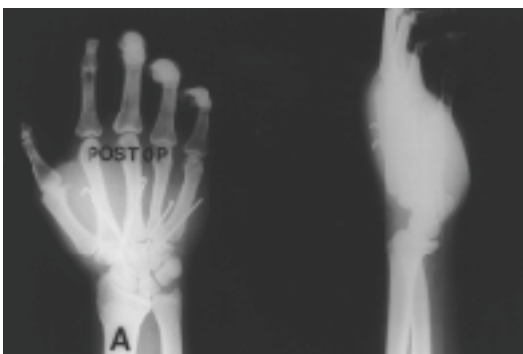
Closed reduction and internal fixation of carpometacarpal joints excluding thumb(A ; Plain AP and lateral view, B ; Post operative CT scan)
